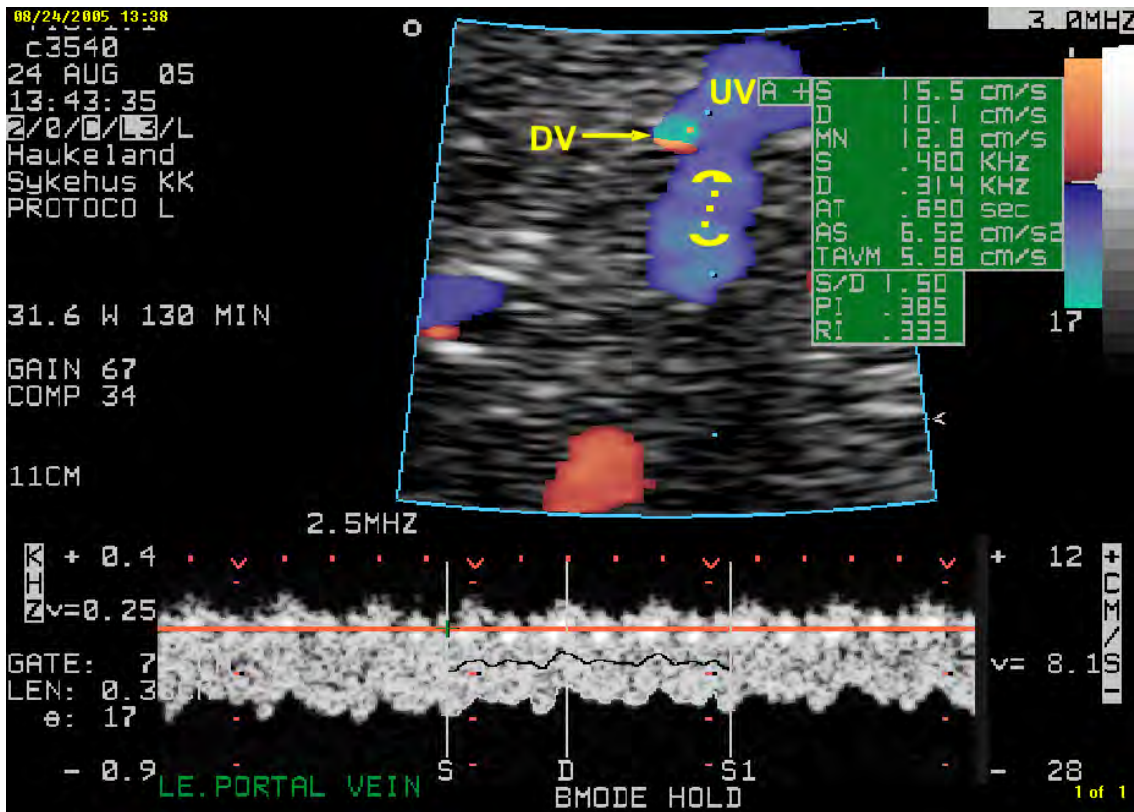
Pulsed Doppler recording of the left portal vein at 31+6 weeks of gestation. The sample volume is placed immediately distal to the branching site of the ductus venosus (DV) to avoid simultaneous recording of velocities of the main stem or the right branch of the portal vein. UV: umbilical vein
